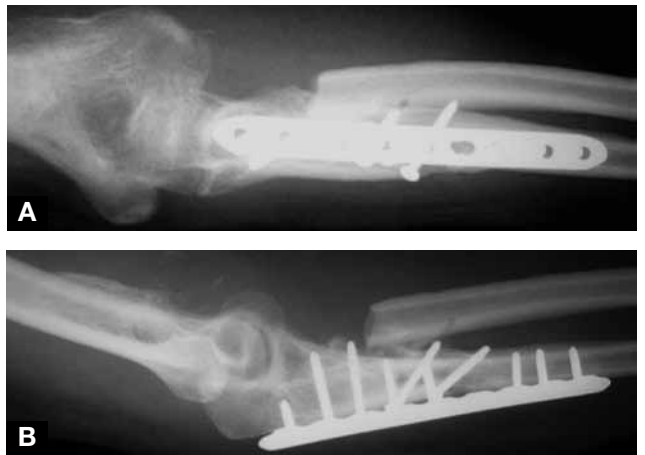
Final postoperative (A) anteroposterior and (B) lateral radiographs show synostosis removal, radial head resection, and realignment of forearm with ulnar osteotomy.
